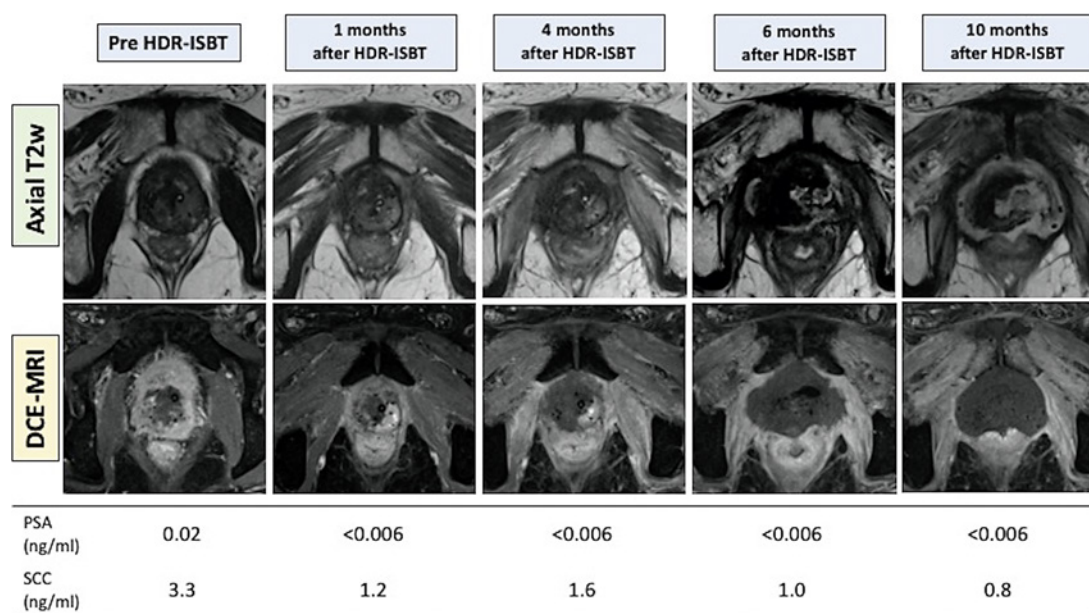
Time course of MRI and serum PSA and SCC data. MRI at 1, 3, 4, and 6 months after HDR-ISBT and EBRT revealed significant decrease in size and/or enhancement of the cancerous lesions. PSA, prostate-specific antigen; SCC, squamous cell carcinoma; HDR-ISBT, high-dose-rate interstitial brachytherapy; EBRT, external beam radiation therapy.
